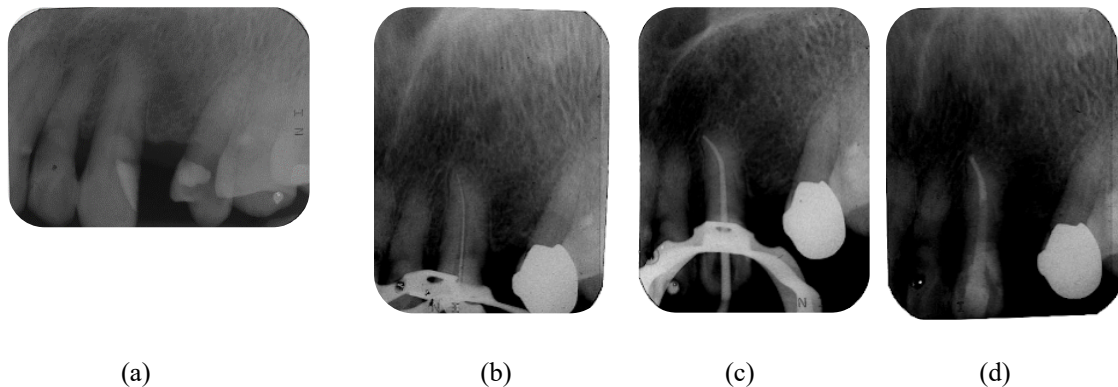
Radiographic sequence of root canal treatment for tooth 23
